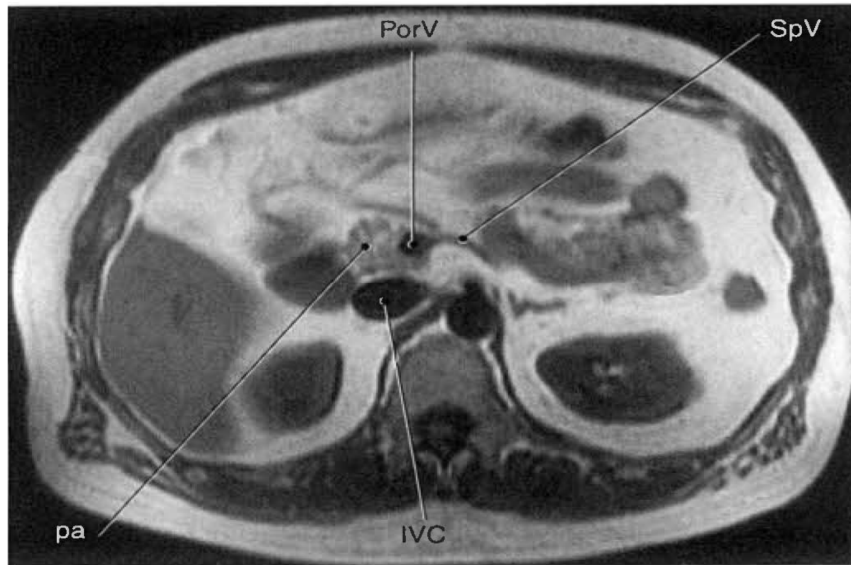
Axial, T1-weighted MR scan of abdomen with portal and splenicveins.
